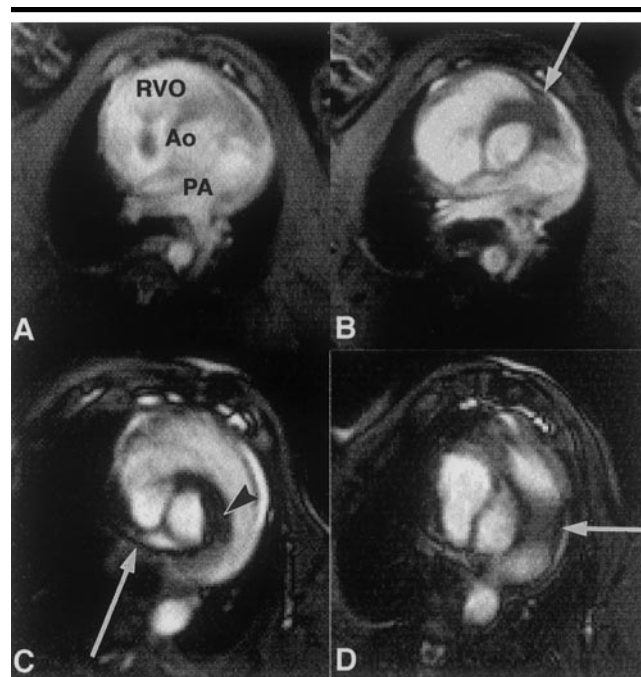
Series of oblique transverse balanced fast field-echo MR images (3.4/1.7, 7-mm-thick sections). A, Image obtained through right ventricular outflow tract (RVO) and pulmonary artery (PA). Ao = aorta. B, Image shows guide wire and stent delivery system across pulmonary valve (arrow). C, Stent was released when tip of application system (arrowhead) was seen approximately 10 mm distal to the pulmonary valve (arrow). D, Image shows stent (arrow) immediately after deployment.
